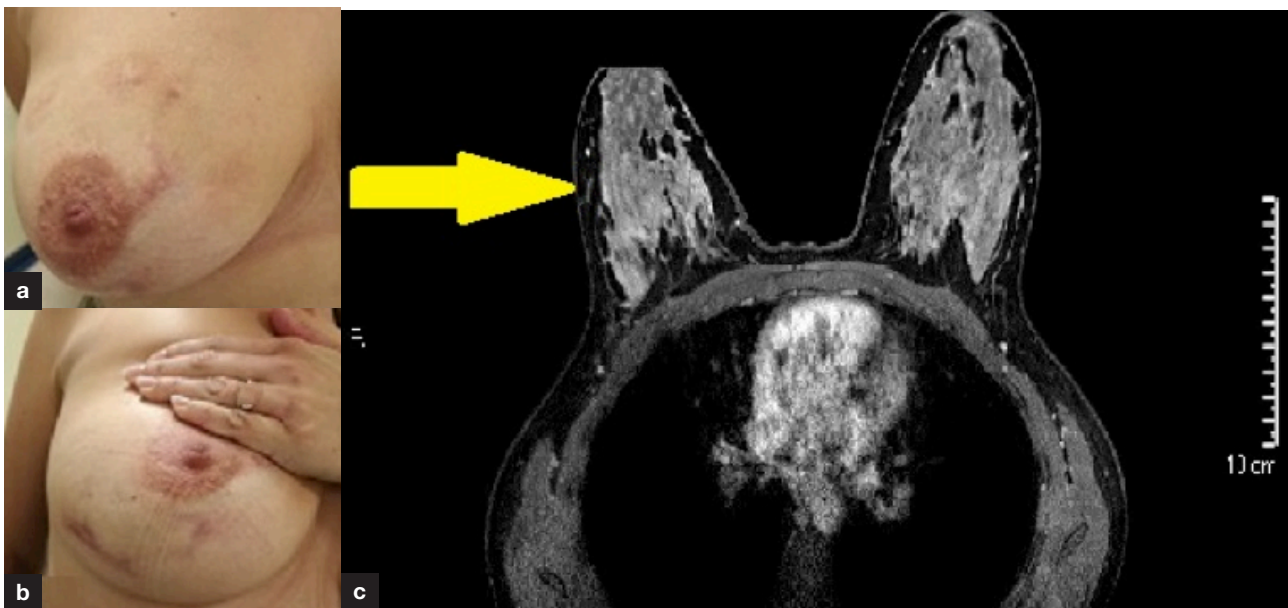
a and b. Post treatment clinical and (c) radiological normal right breast on magnetic resonance imaging – T2 sequence (yellow arrow).
